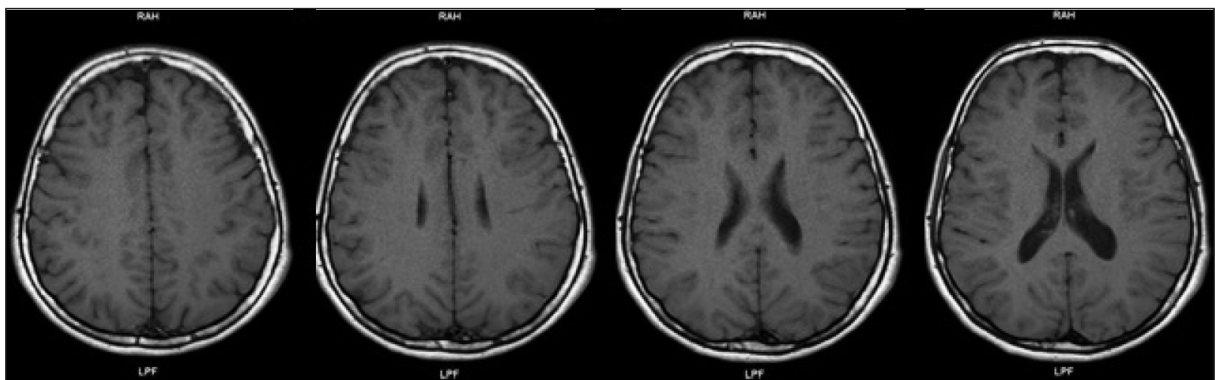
MRI images of the patient (axial section).
